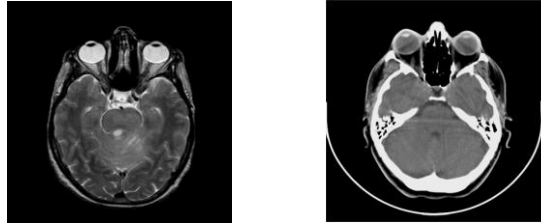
Multimodal Images (MRI & CT).
